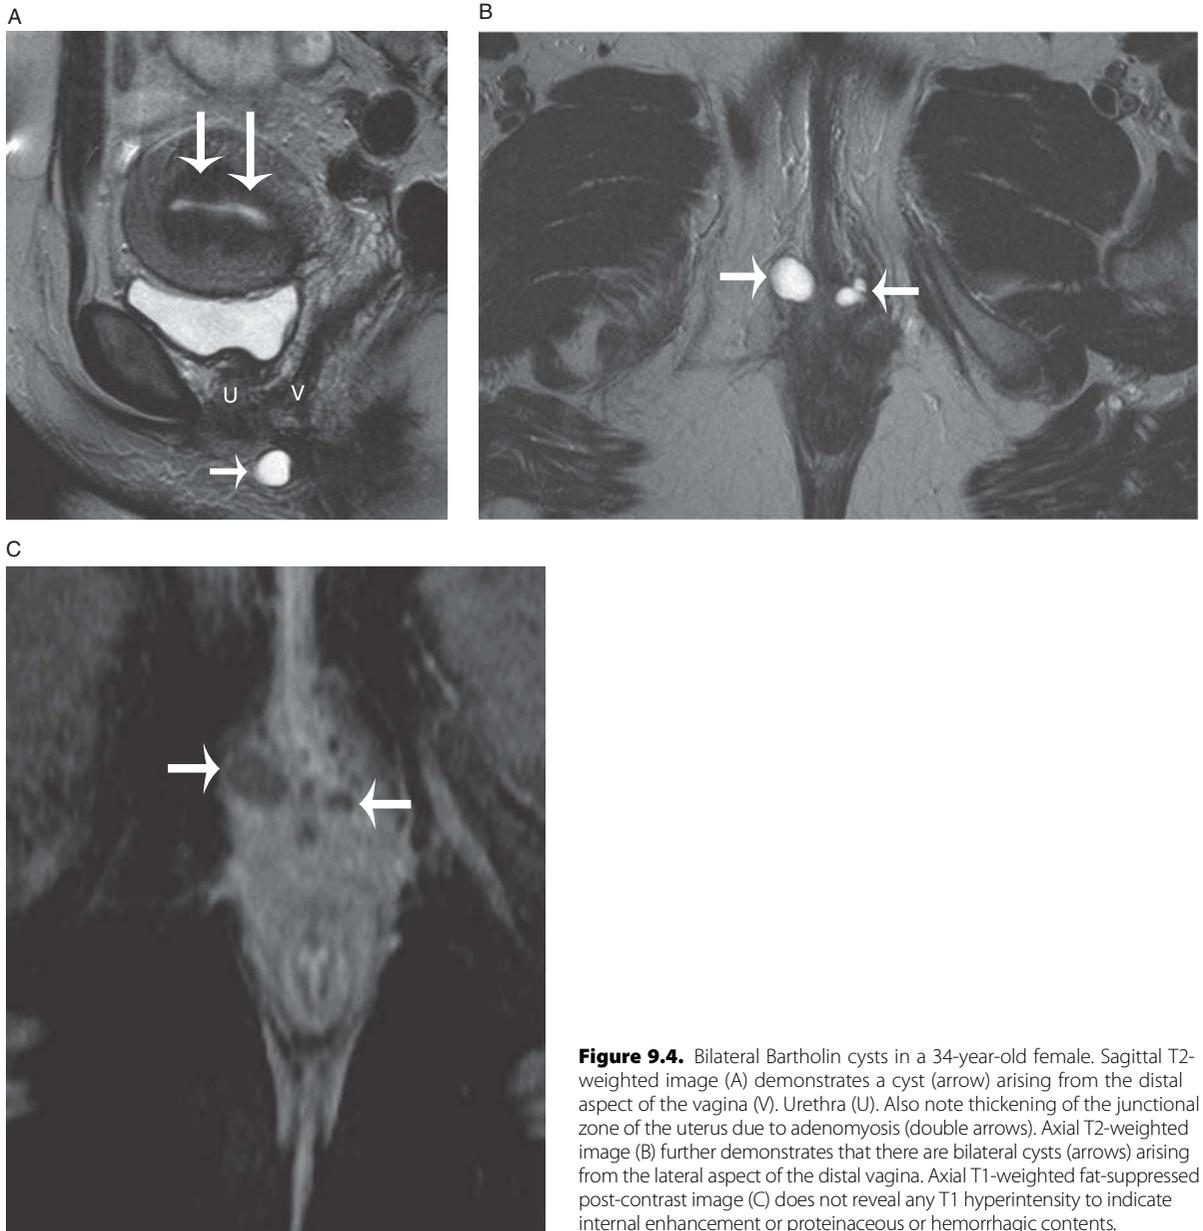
Bilateral Bartholin cysts in a 34-year-old female. Sagittal T2-weighted image (A) demonstrates a cyst (arrow) arising from the distal aspect of the vagina (V). Urethra (U). Also note thickening of the junctional zone of the uterus due to adenomyosis (double arrows). Axial T2-weighted image (B) further demonstrates that there are bilateral cysts (arrows) arising from the lateral aspect of the distal vagina. Axial T1-weighted fat-suppressed post-contrast image (C) does not reveal any T1 hyperintensity to indicate internal enhancement or proteinaceous or hemorrhagic contents.
